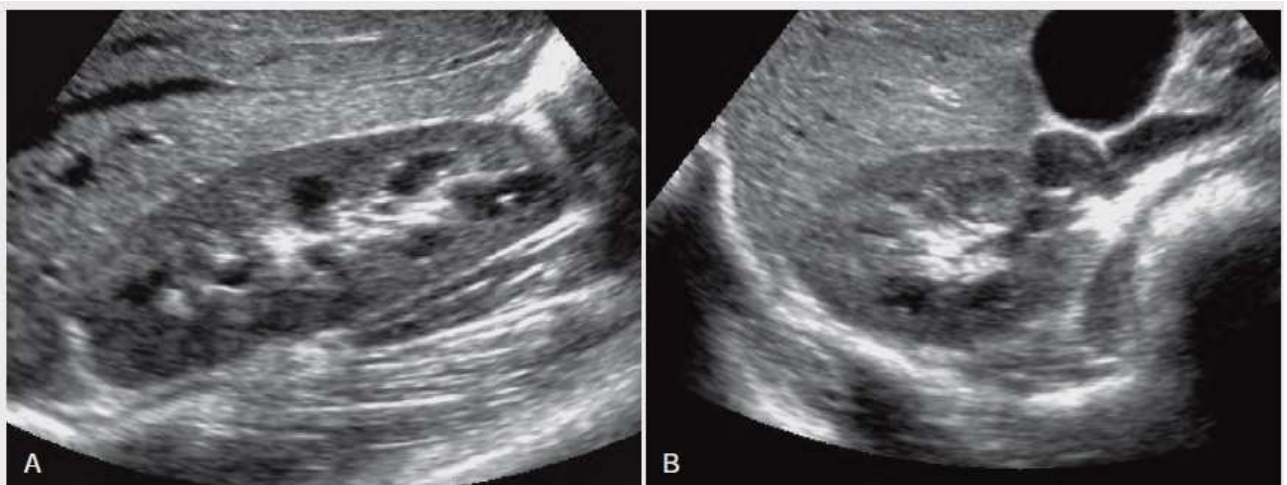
(2.6): normal sonographic image of kidney: A, Sagittal, and B, transverse, sonograms of normal anatomy with corticomedullary differentiation show
